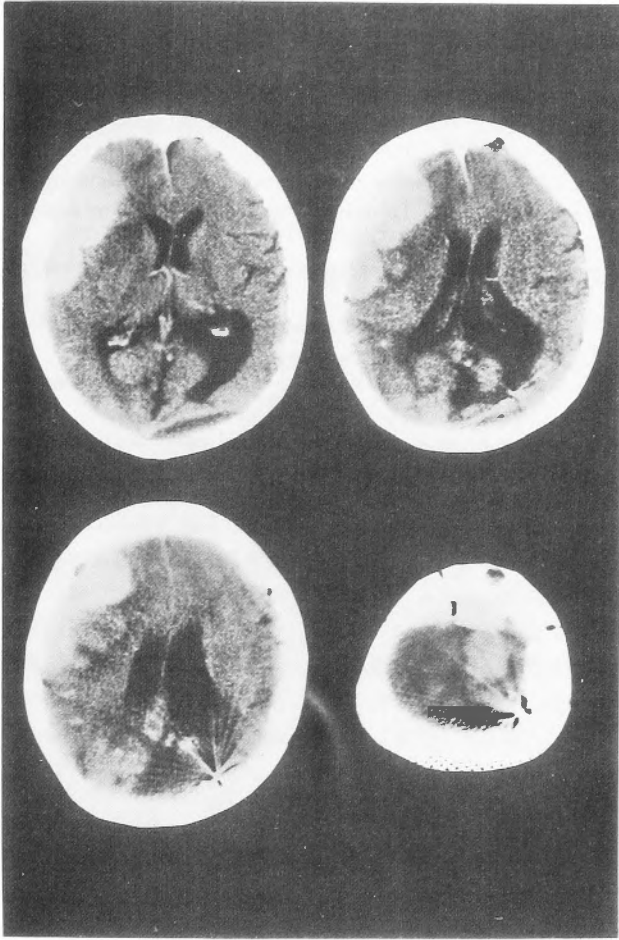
Enhanced CT on the seventh admission. Multiple tumors are seen in the right frontal convexity, in the bilateral occipital convexity and on the left side of the parietal falx. The midline shift is also recognized.
